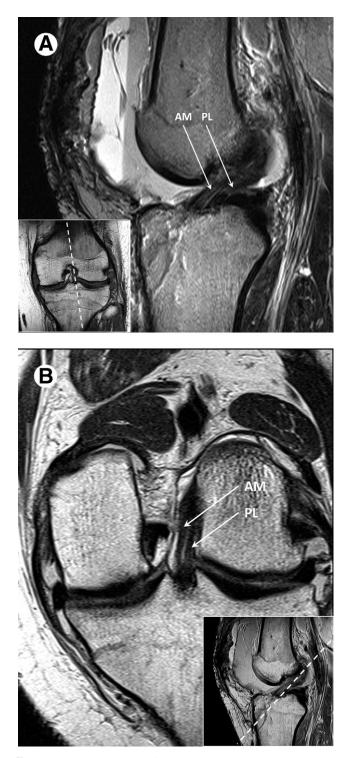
Special orientation of the MRI slices allows better visualization of the ACL. (A) Oblique sagittal slice revealing both the AM and PL bundles. (B) Oblique coronal slice. The AM and PL bundles are identified.
